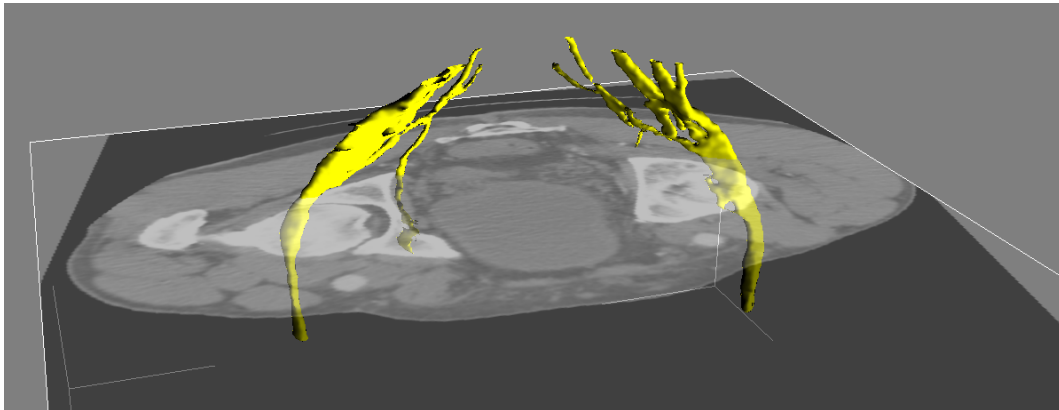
Using our approach, the nerves that were segmented in the cryosectional images can be mapped to unseen patient specific CT-scan data. The location of these nerves is not visible in the original CT-scan.
